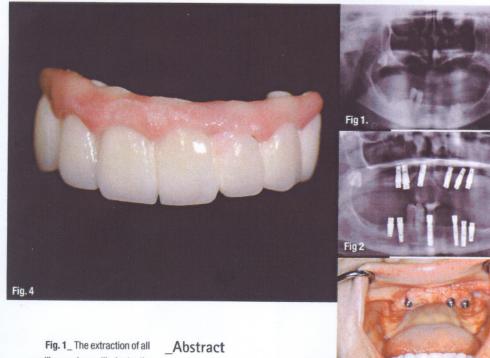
1_ The extraction of all maxillary and mandibular teeth, except #43 and #44. Fig. 2_ Panoramic x-ray of 6 upper jaw and 6 lower jaw implants. Fig. 3_ The maxilla after loss of 3 implants.
